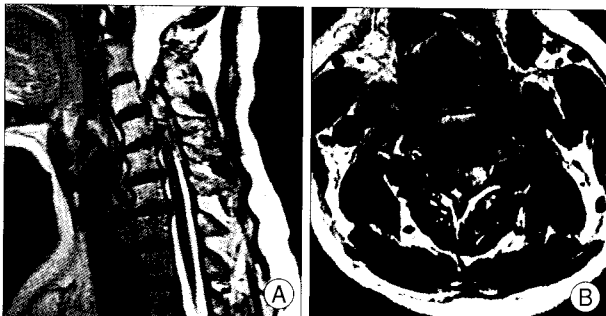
Case 1. A : Preoperative sagittal T2-weighted image shows epidural hematoma at C2-C5. B : Axial T2-weighted image demonstrates hematoma with cord displacement.
